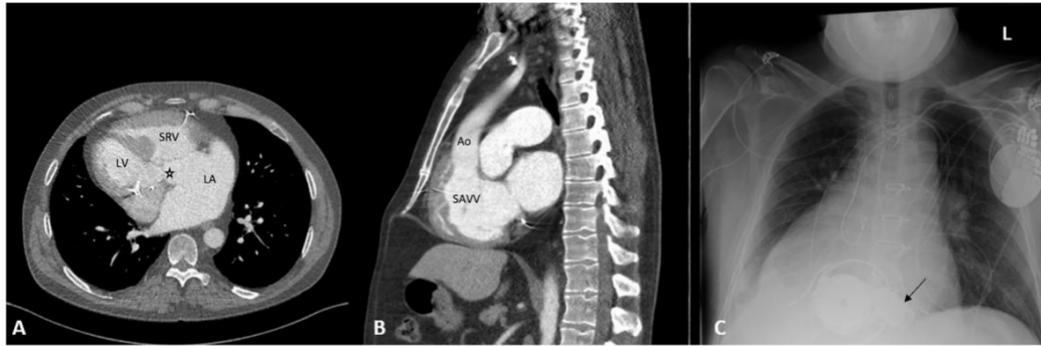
Pre-operative CT images of the heart on axial (A) and sagittal (B) views. A post-operative chest x-ray of the heart with SRV VAD is displayed (C). Image (A) shows the anterior position of the SRV within the left hemithorax due to dextrocardia. Displacement of the SAVV septal leaflet to the septal wall & VSD (star label) is also shown. Image (B) shows the orientation and proximity of the SAVV with the anterior ventricular wall & apex. The final position of the VAD inflow cannula (arrow notation) ensured adequate alignment with the SAVV replacement and septum (C).
